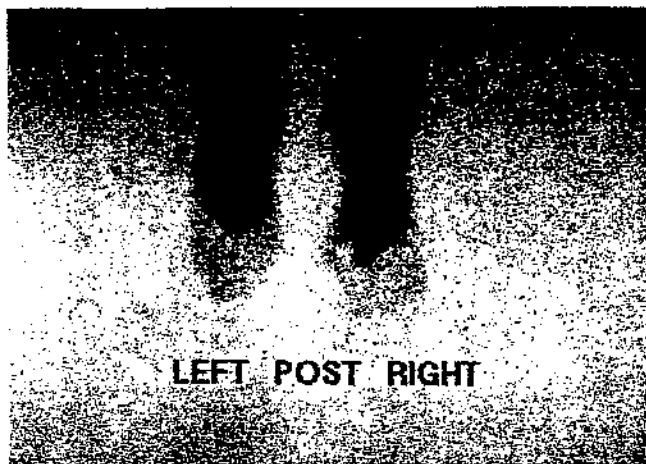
The delayed phase of the technetium bone scan demonstrating increased uptake in the second metatarsal neck. This is the bone scan of the patient whose plain radiographs are seen in Figure 1.
